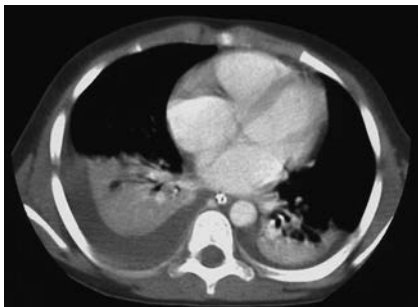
Chest CT showing bilateral haemothorax and lung contusion secondary to blunt trauma.
